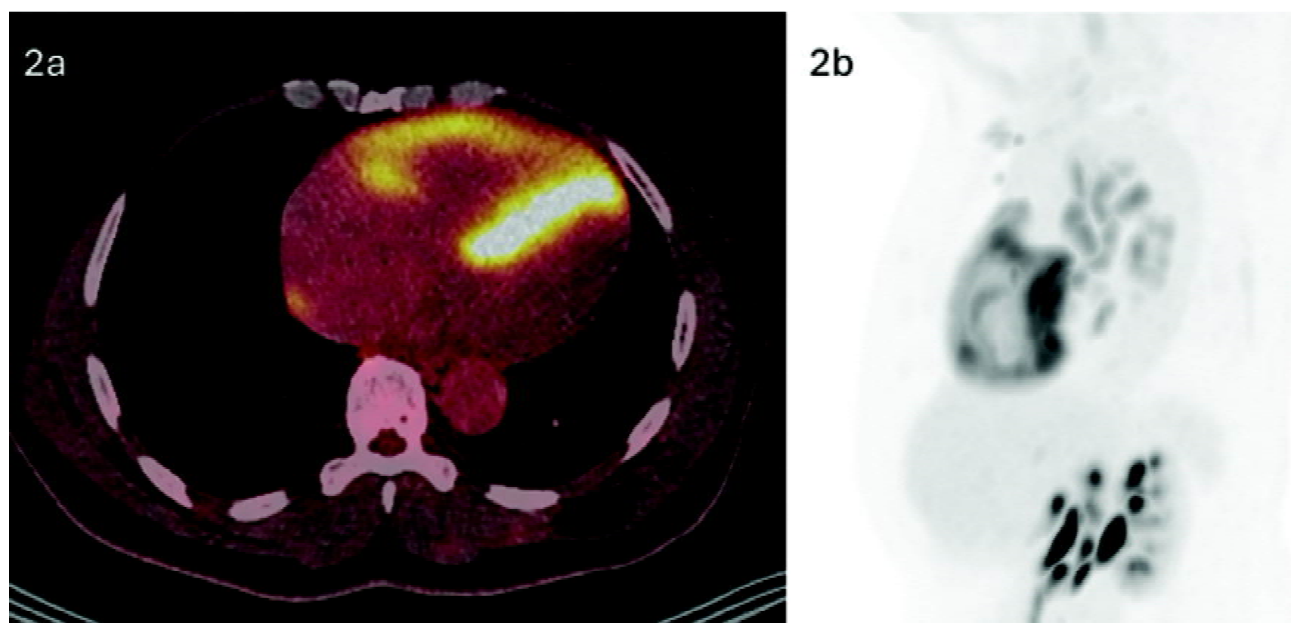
FDG-PET/CT in cardiac sarcoidosis demonstrating a rare but recognised pattern of diffuse right ventricular and septal FDG uptake. (a) Axial fused PET/CT image showing intense FDG avidity along the right ventricular free wall and interventricular septum. (b) Maximum intensity projection (MIP) image confirming diffuse cardiac uptake and demonstrating FDG-avid mediastinal and hilar lymphadenopathy.
